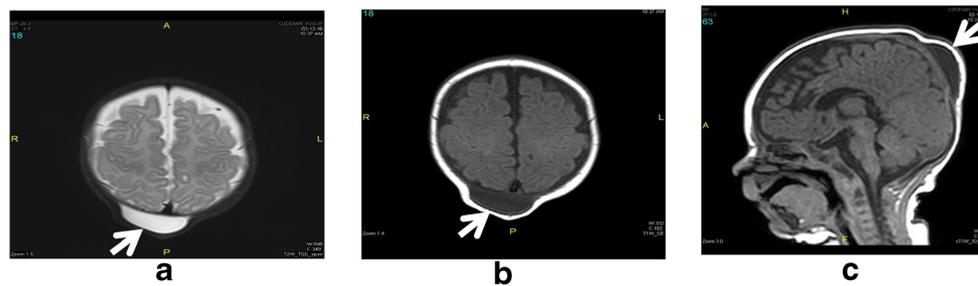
Brain magnetic resonance imaging of case 2 showing subaponeurotic fluid collection located at the right parieto-occipital region and crossing the sagittal suture. a Axial T2-weighted image. b Axial T1-weighted image. c Sagittal T1-weighted image
